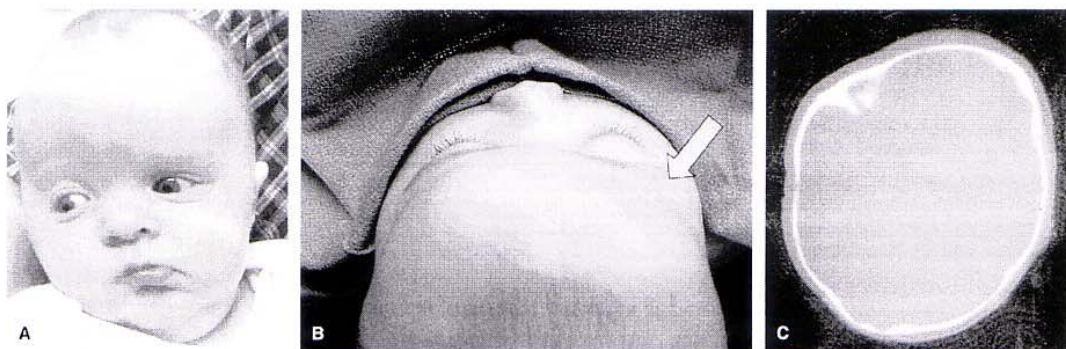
(A) Patient with right unilateral coronal synostosis before surgery. Note flattened, recessed, and elevated supraorbital rim. (B) Preoperative view: note the flattened and recessed right supraorbital rim. (C) CT scan with right unilateral coronal synostosis before surgery.
